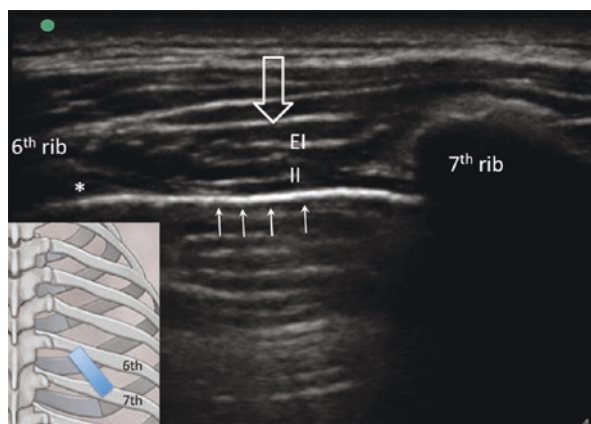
(a) The intercostal muscles. EI external intercostal, II internal intercostal, pleura indicated by arrows. Bold arrow represents the fascia over the external intercostal muscle. (b) shows a similar sonogram in an obese patient. * represents the target location for the fascial plane between the internal intercostal and innermost intercostal muscles, or deep to the internal intercostal when the innermost intercostal is not well visualized. (Reprinted with permission from Philip Peng Educational Series)
